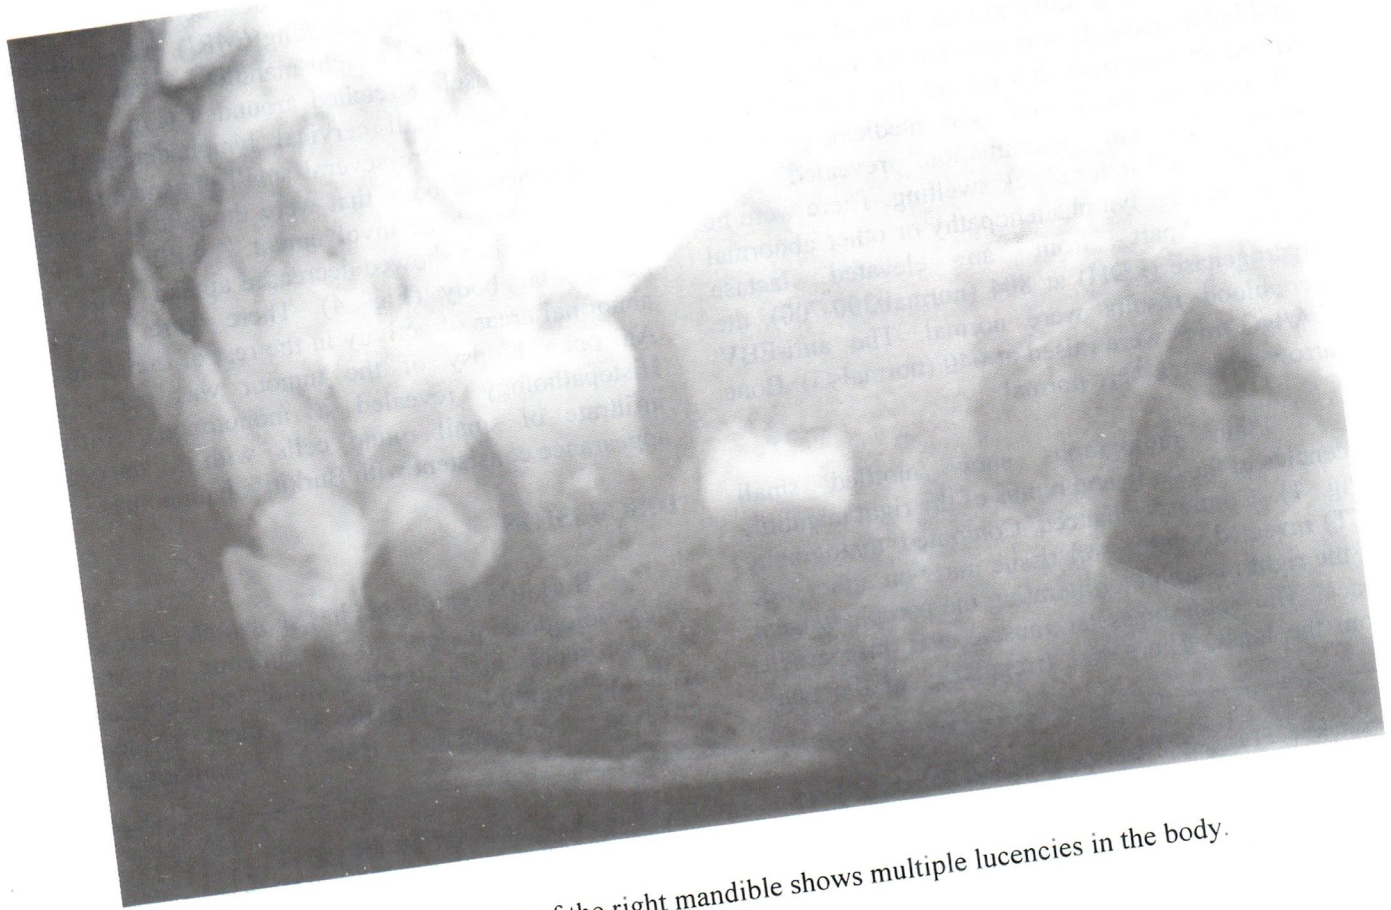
Radiograph of the right mandible shows multiple lucencies in the body.
